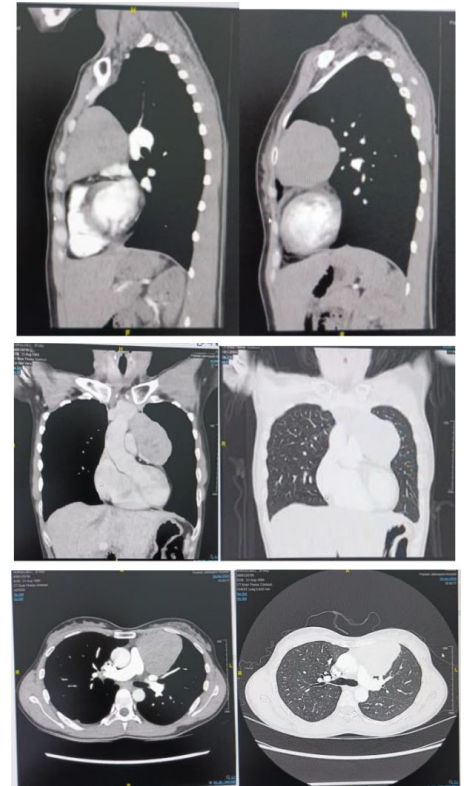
Chest CT Scan Contrast Before Operation.
